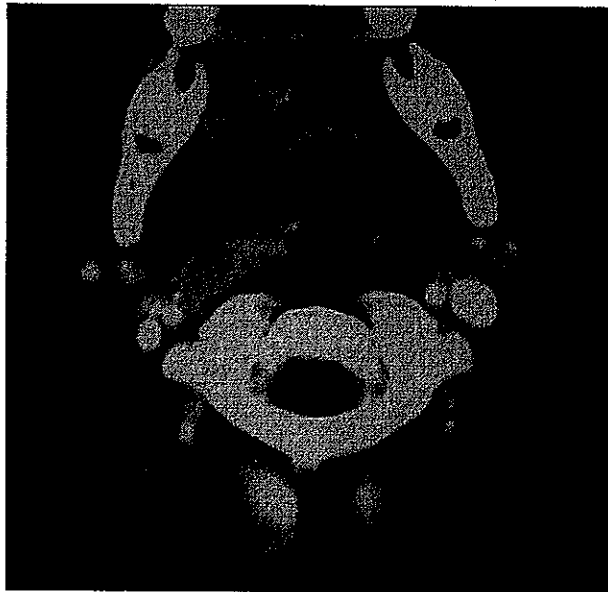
Computed tomographic scan of oropharyngeal soft tissue showing a large right peritonsillar abscess.
